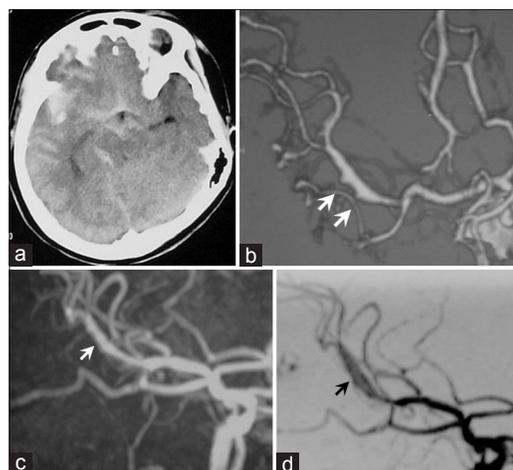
(a) CT showing SAH dominantly on the right side. (b) 3D-CTA showing a dilatation of M2 of the right MCA. Two small notches can be seen on the main lesion (arrows). (c) MRI 4 months before SAH showing an abnormality on the right M2 portion (arrow). (d) MRI on admission showing a dilatation of M2 (arrow)
